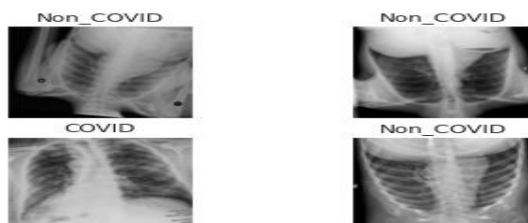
Random Augmented Xray images
